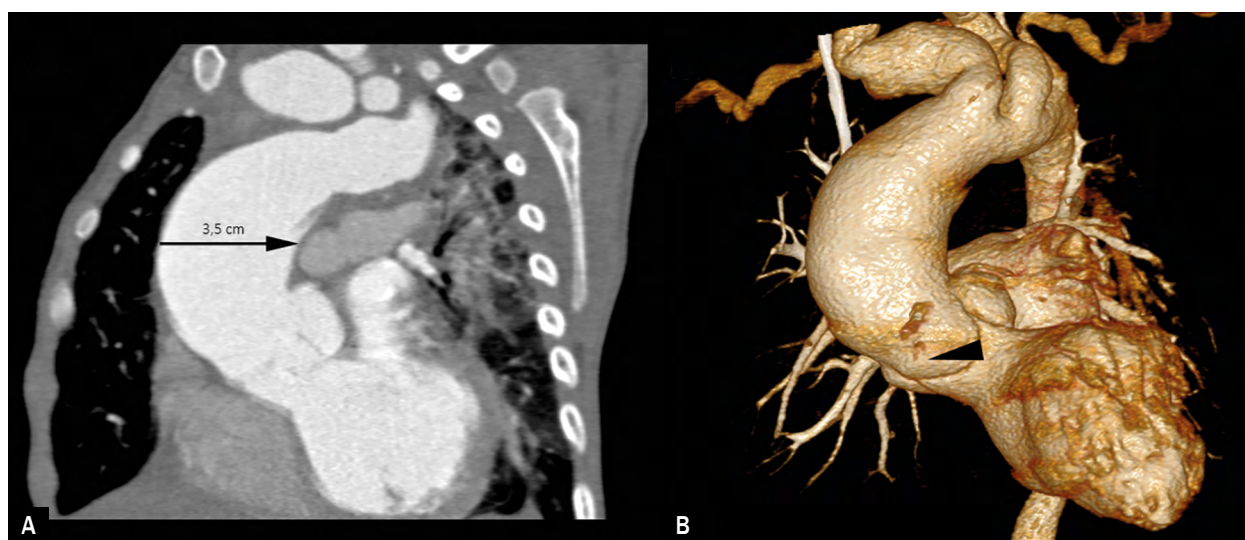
Multislice CT angiography of an aortic arch aneurysm in a 20-month-old boy with suspected Marfan syndrome; A. Sagittal CT angiogram; B. 3D volume rendering image show ascending aorta with a maximum diameter of 3.5 cm (arrow), a significant enlargement of the aortic root and moderately dilated three sinuses of Valsalva (arrowhead) with severe aortic regurgitation; CT – computed tomography
